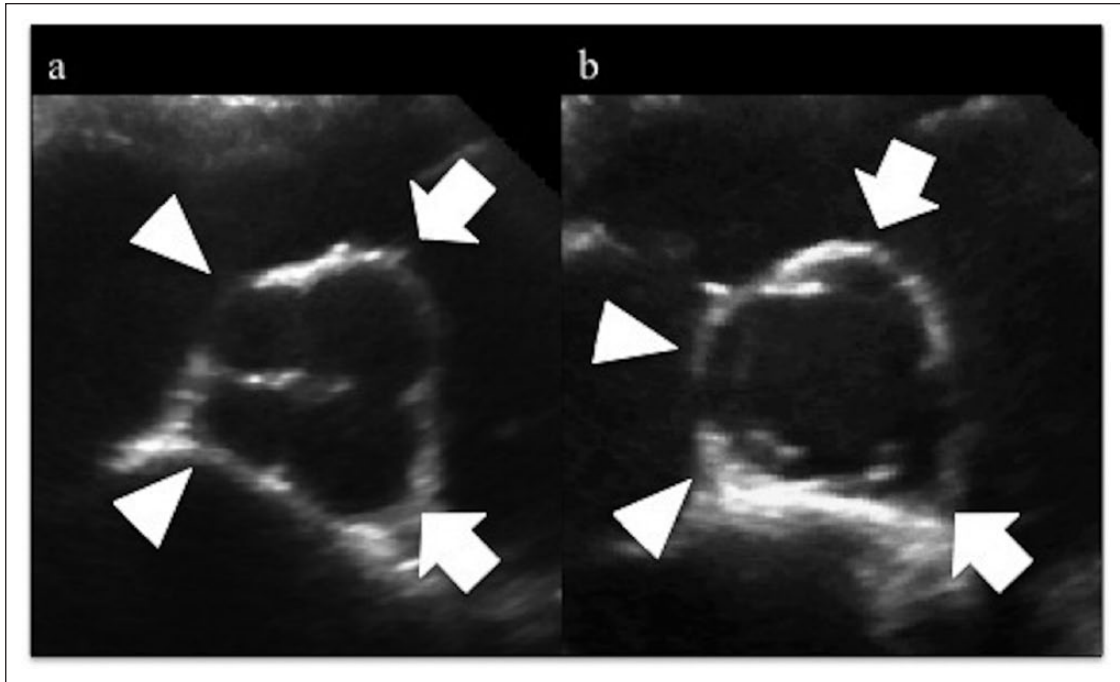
Two-dimensional echocardiographic images from the right parasternal short-axis view at the aortic valve level during (a) diastole and (b) systole showing two equally large (arrows) and two equally small (arrowheads) aortic valve cusps
